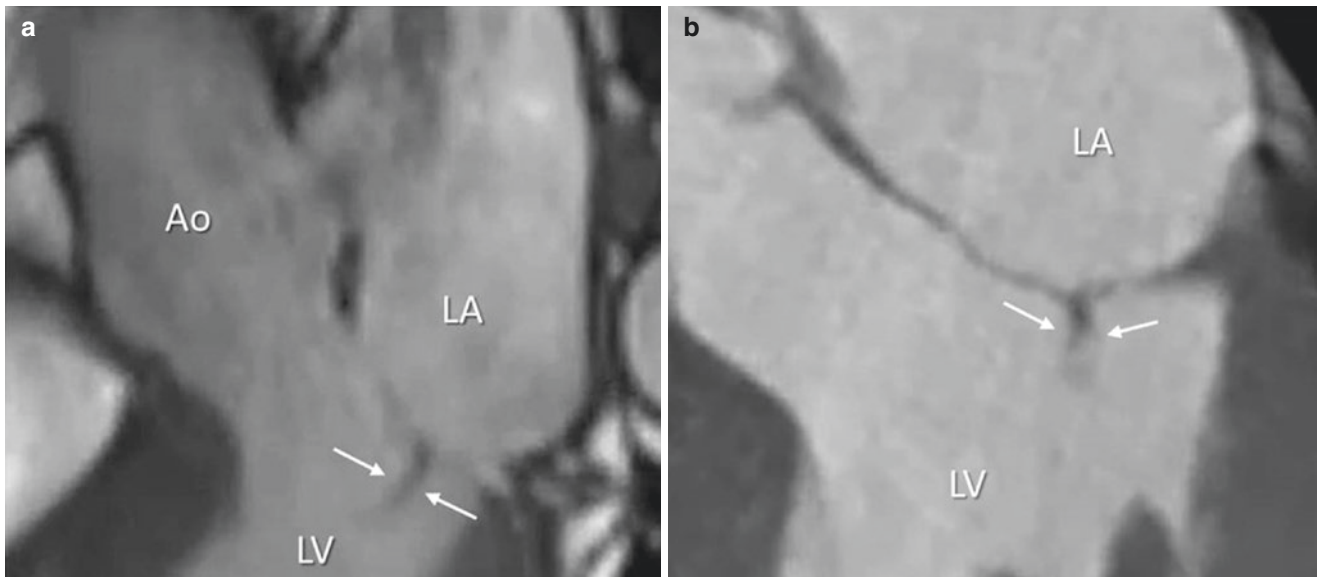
CMR image (a) and CT scan (b) showing the coaptation surface (*arrows*) in systole. *Ao* aorta, *LA* left atrium, *LV* left ventricle
